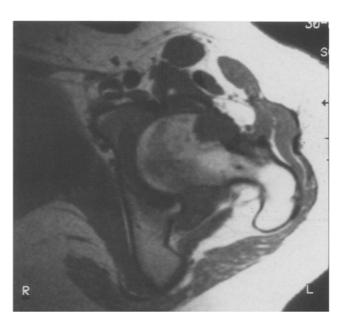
Transverse MRI scan of both hips, T1 sequence. The nidus and the swelling and thickening of the joint capsule are seen in the left hip.
